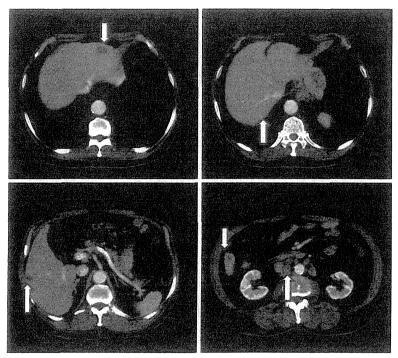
化学療法前腹部 CT 残胃全体の壁肥厚あり。肝 S3, S5, S6 に多発の肝転移を認め, 残胃小弯 ならびに大動脈周囲 (No. 16) に多数のリンパ節の腫大を認めた。
